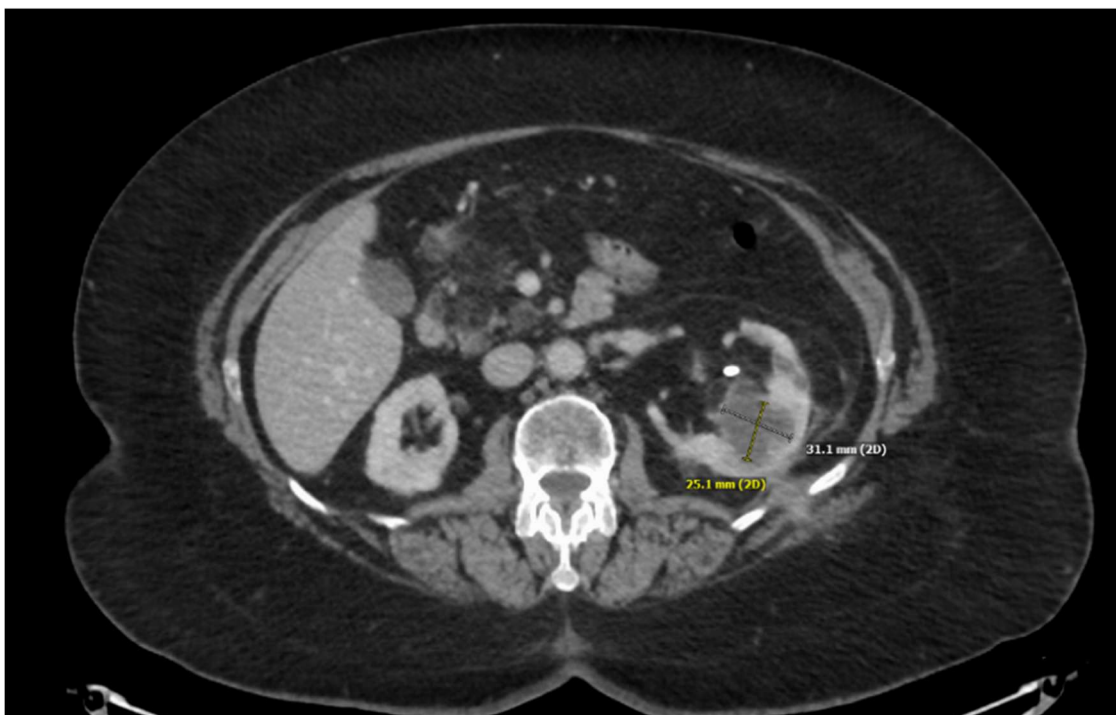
CT scan indicates abscess in left mid pole kidney with NCF.
